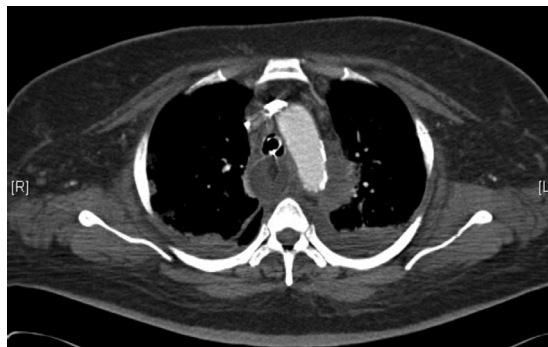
Axial CT image shows a haematoma around the aortic arch.
